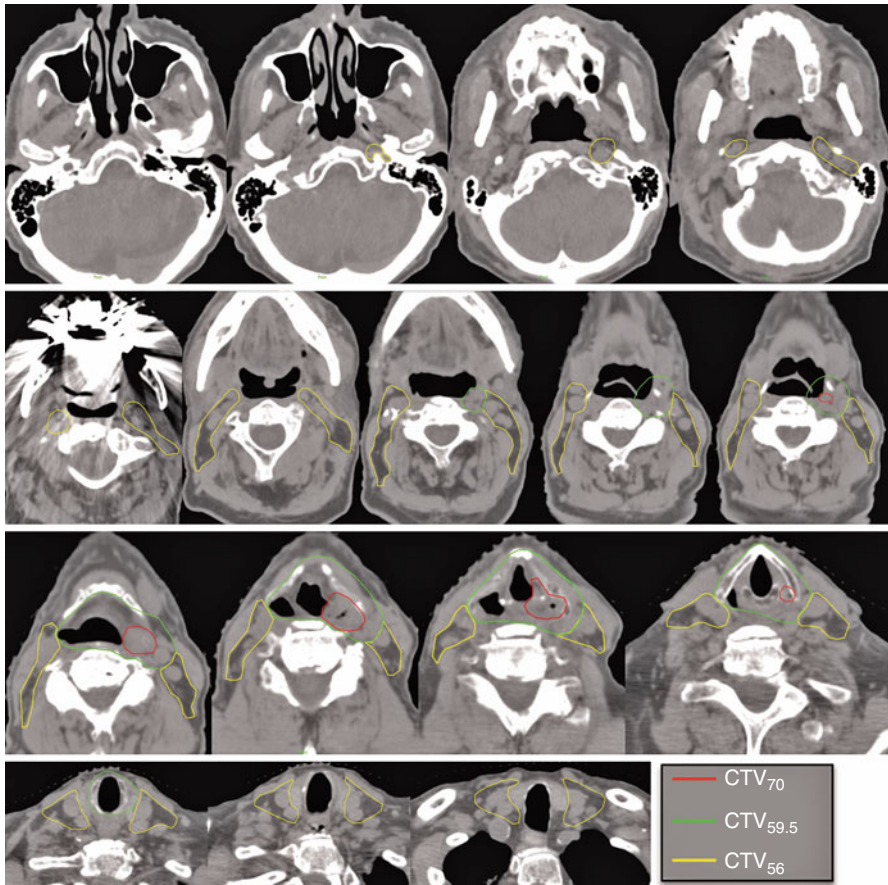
Early-stage T2N0 left pyriform sinus HNSCC. The principles of targeting early-stage hypopharyngeal cancers are shared among all subsites. It is critical to perform multiple imaging studies including CT with IV contrast, MRI, and/or PET to confirm with highest certainty that there is no detectable nodal disease. For high confidence cN0 disease, the bilateral neck may receive the lower-risk RT dose, e.g., 56 Gy
